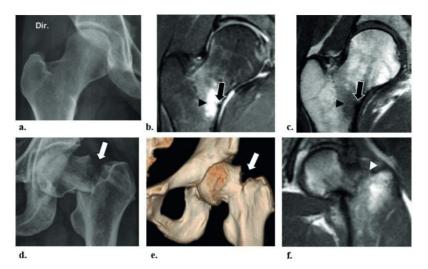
Low and high-risk femoral fractures. 34-year-old woman complaining of pain in her right hip, beginning three weeks before, while exercising. AP radiograph of the right hip (a) does not show direct signs of fracture. However, proton density-weighted coronal MRI (PD), with fat saturation (b) and T1 coronal MRI (c) demonstrate a linear fracture line (black arrows) with low signal, in the inferomedial femoral neck cortical, surrounded by edema of the adjacent bone marrow (black arrowheads) that exhibits high signal in PD and low signal in T1. - Another female patient, 49 years old, with pain in the anterior compartment left thigh root, of insidious character and worsening for one week after running. Radiograph of the left hip in AP (d) and CT with 3D reconstruction (e) reveal evolution to complete fracture of the superolateral femoral neck cortex (white arrows), with signs of bone misalignment. T1-weighted coronal MRI (f) shows the extensive fracture line (white arrowhead) with low signal, associated with changes in bone angulation / axis in this region.
